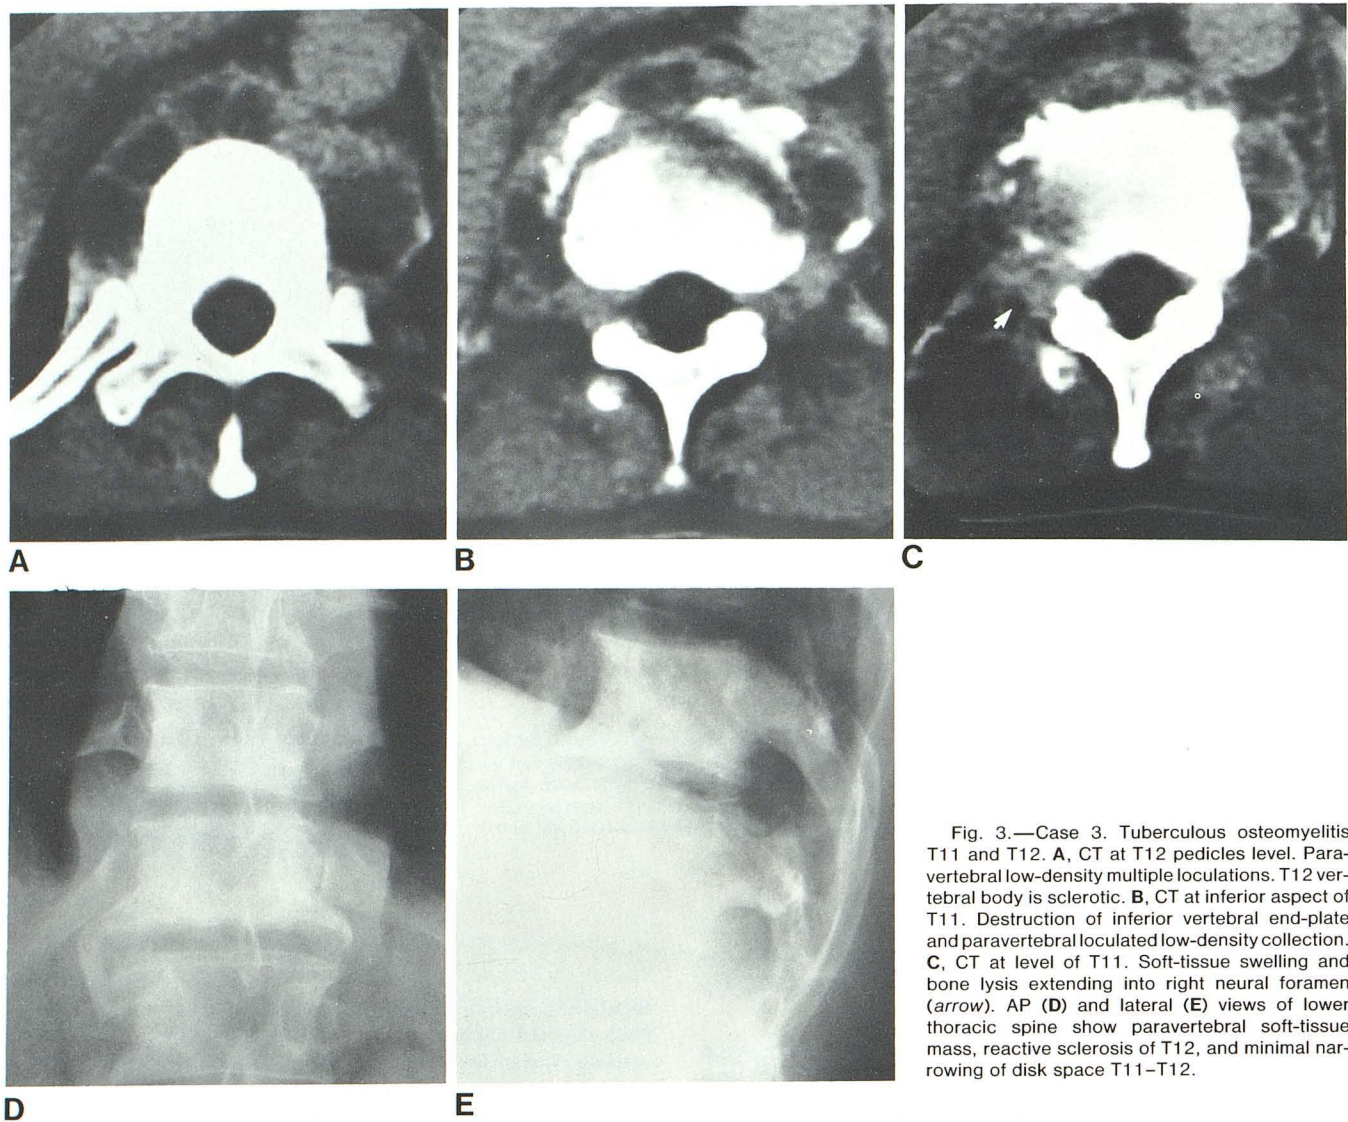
Case 3. Tuberculous osteomyelitis T11 and T12. A, CT at T12 pedicles level. Paravertebral low-density multiple loculations. T12 vertebral body is sclerotic. B, CT at inferior aspect of T11. Destruction of inferior vertebral end-plate and paravertebral loculated low-density collection. C, CT at level of T11. Soft-tissue swelling and bone lysis extending into right neural foramen (arrow). AP (D) and lateral (E) views of lower thoracic spine show paravertebral soft-tissue mass, reactive sclerosis of T12, and minimal narrowing of disk space T11–T12.
